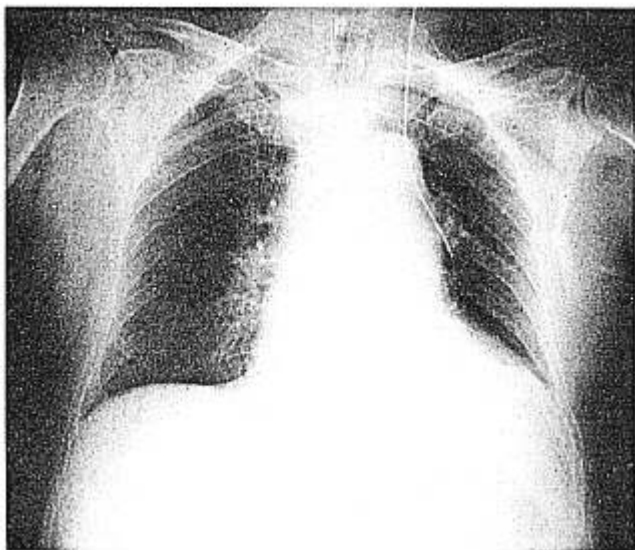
Initial chest roentgenogram showing the location of the catheter.
